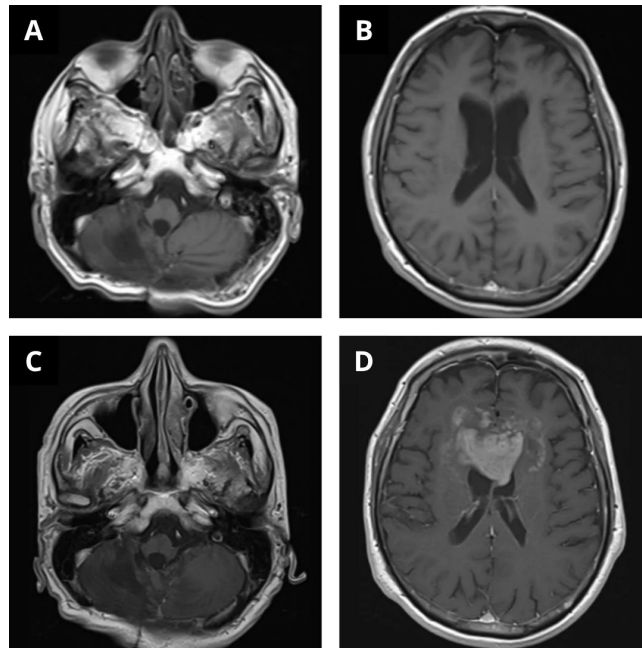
Axial contrast-enhanced T1-weighted brain MRI (T1 + C). (A) Infratentorial image showing postsurgical changes from the 2022 suboccipital craniectomy and tumor excision in the right cerebellar hemisphere, with cerebellomalacia, gliosis, and volume loss, without abnormal enhancement. (B) Supratentorial image from the 2022 postoperative MRI, showing no lesions or abnormal contrast enhancement at the corpus callosum. (C) Infratentorial image at 2024 follow-up showing stable postoperative changes, without evidence of recurrent enhancing lesion in the posterior fossa. (D) Supratentorial image at 2024 follow-up showing a new infiltrative, heterogeneously enhancing lesion involving the genu and body of the corpus callosum, crossing the midline (“butterfly” pattern), suggestive of a high-grade glioma.
